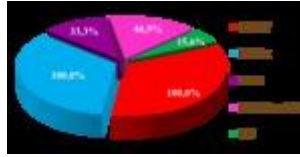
CBCT-images have been compared with the data of MSCT, MRI, US, DMFR and SR of...
